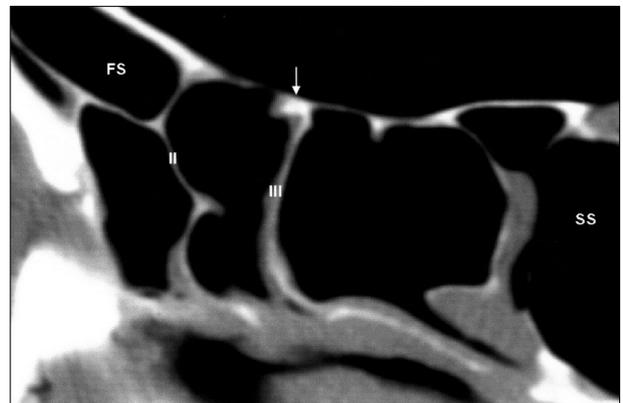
A sagittal computed tomograph. The anterior ethmoid canal (arrow) was located attaching to the skull base in the third lamella.
